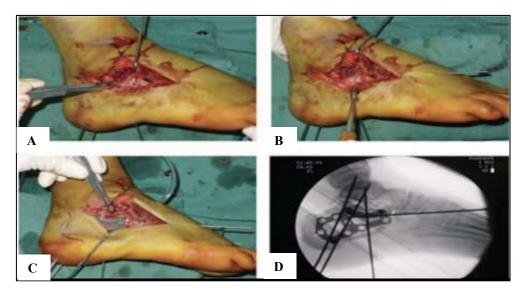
(A-D): DICAFs with involvement of the calcaneocuboid joint. (A) the skin incision was stretched anteriorly to expose the calcaneocuboid joint, (B) the relocated calcaneocuboid joint was fixed with K-wires, (C) internal fixation with a plate or screw or k-wire, (D) postoperative lateral X-ray indicated that calcaneus was reduced properly and the insertion of CC screw=displaced intra-articular calcaneal fractures.
